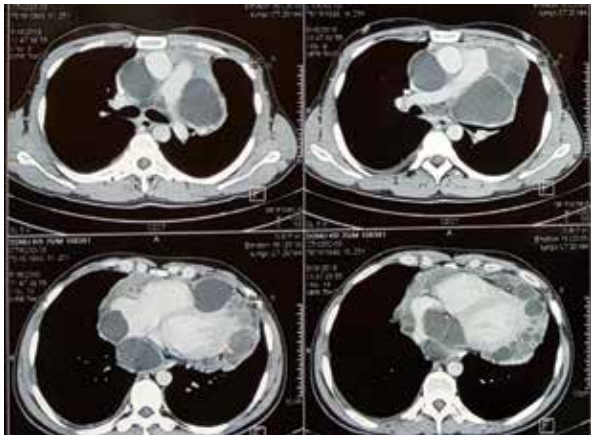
Contrast enhanced computed tomography of the chest showing multiple cystic lesions adjacent to the pulmonary trunk, aorta and pericardiac region with extrinsic indentation over the cardiac chambers.
